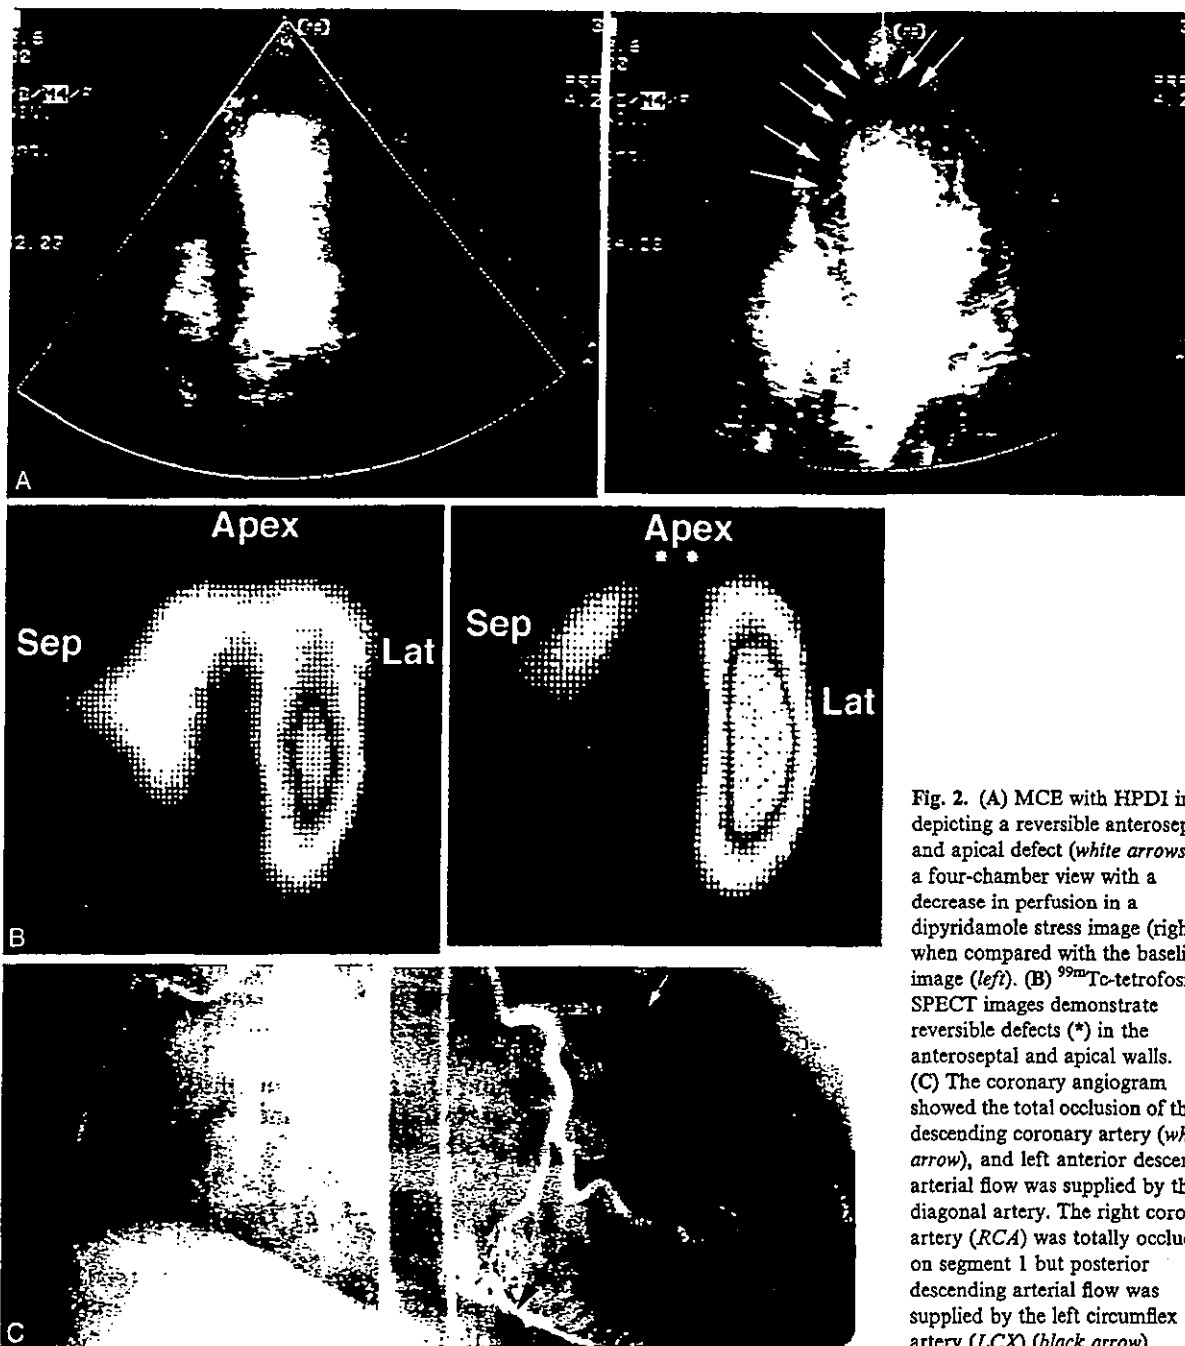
(A) MCE with HPDI image depicting a reversible anteroseptal and apical defect (white arrows) in a four-chamber view with a decrease in perfusion in a dipyridamole stress image (right) when compared with the baseline image (left). (B) <sup>99m</sup>Tc-tetrofosmin SPECT images demonstrate reversible defects (\*) in the anteroseptal and apical walls. (C) The coronary angiogram showed the total occlusion of the left descending coronary artery (white arrow), and left anterior descending arterial flow was supplied by the 1st diagonal artery. The right coronary artery (RCA) was totally occluded on segment 1 but posterior descending arterial flow was supplied by the left circumflex artery (LCX) (black arrow).
